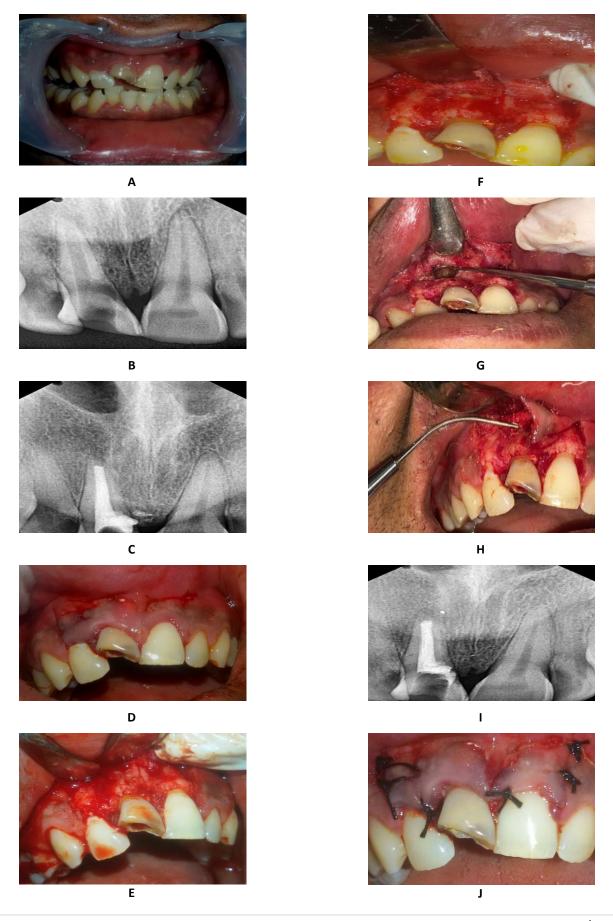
(a) Preoperative clinical photo (b) Pre operative radiograph (c) Obturation done (d) Incision given (e) Flap raised (f) Window created at apex (g) Retrograde cavity preparation (h) MTA retro filling done (i) Radiographic picture of MTA at apex and at perforation area (j) Flap approximation done and sutures given
